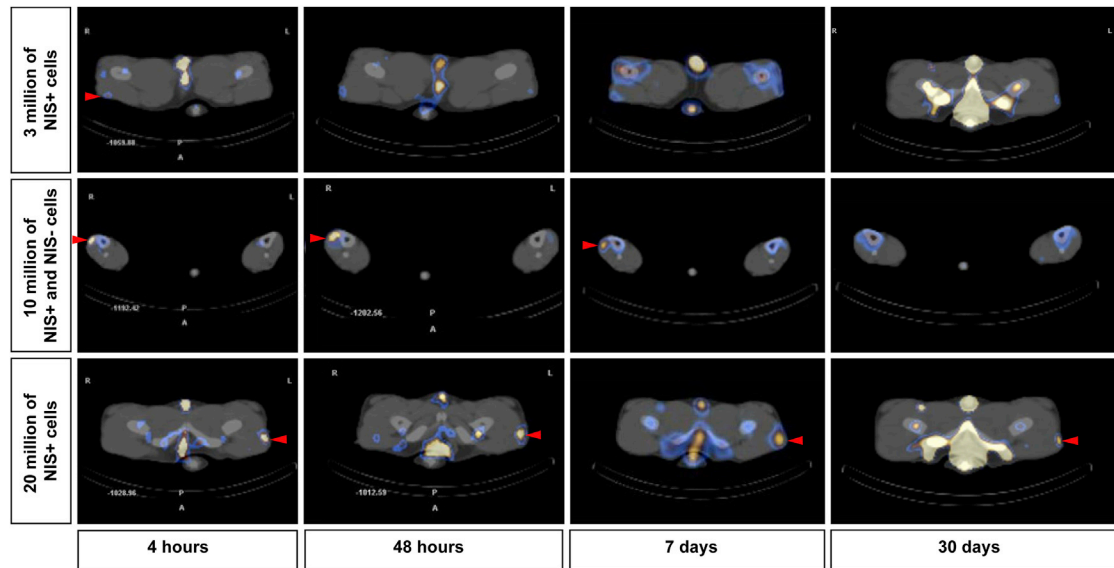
SPECT/CT Scans for cNIS⁺ Cells Visualization
